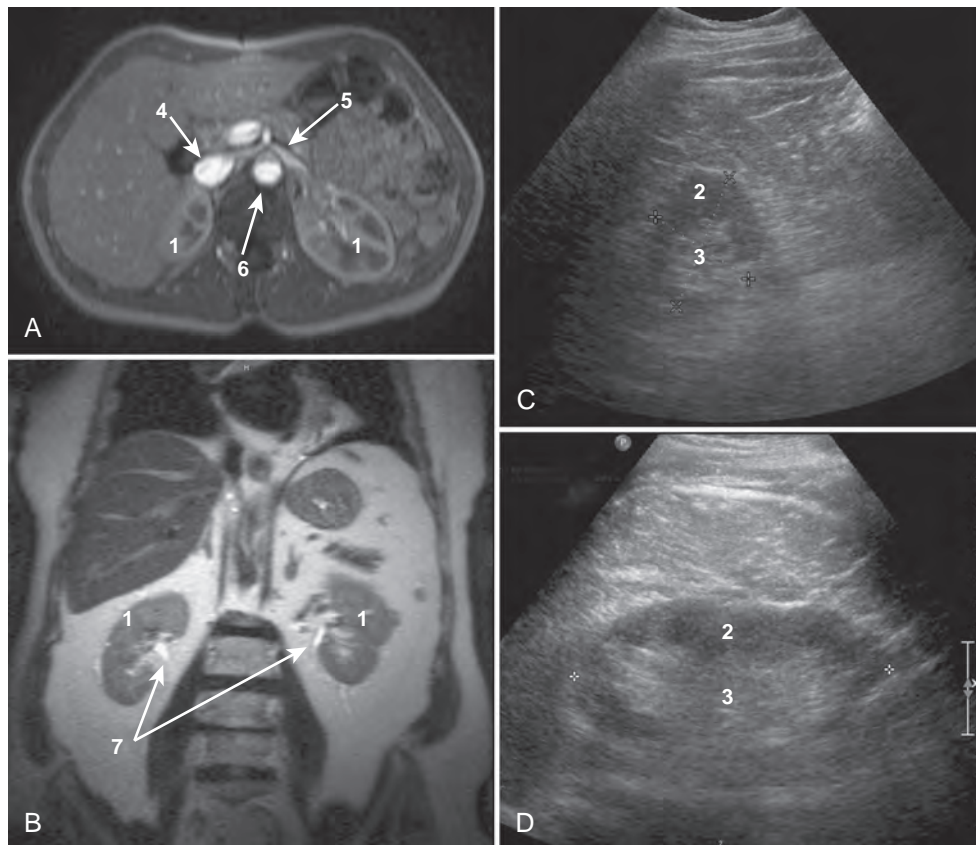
Cross-sectional imaging of the normal kidney. A, T1-weighted gadolinium-enhanced axial magnetic resonance imaging (MRI) of kidneys, including the inferior vena cava, aorta, left renal vein, and superior mesenteric artery. B, Coronal T2 MRI of the kidneys. C, Transverse ultrasound imaging of the kidney. D, Sagittal ultrasound imaging of the kidney. 1, kidney; 2, renal cortex; 3, renal medulla; 4, inferior vena cava; 5, left renal vein; 6, aorta; 7, renal collecting system.
